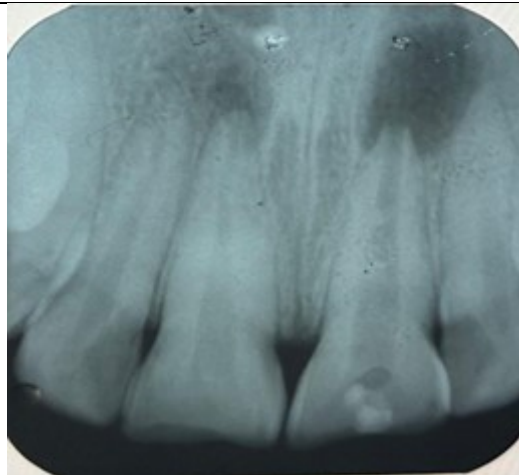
Pre-Operative Radiograph with 21
